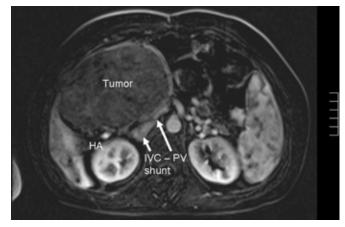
Magnetic resonance imaging showed a large hepatic mass (tumor) and drainage of the portomesenteric vein (PV) into the inferior vena cava (IVC) constituting the congenital portacaval shunt. The hepatic artery (HA) was present at the hilum. No portal vein at the hilum was found.
